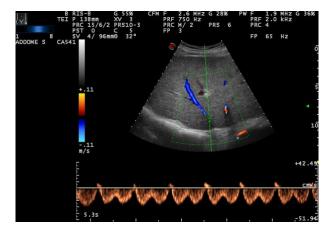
Spectral Doppler trace shows a normal hepatic vein triphasic waveform flow.
